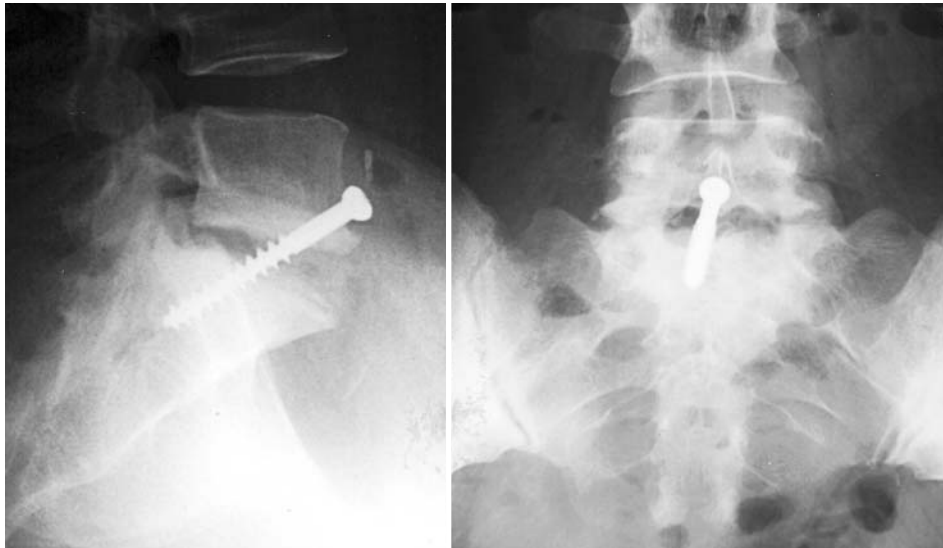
Lateral (*left*) and anteroposterior (*right*) radiographs obtained 3 months after a Wilhelm Tell procedure.
